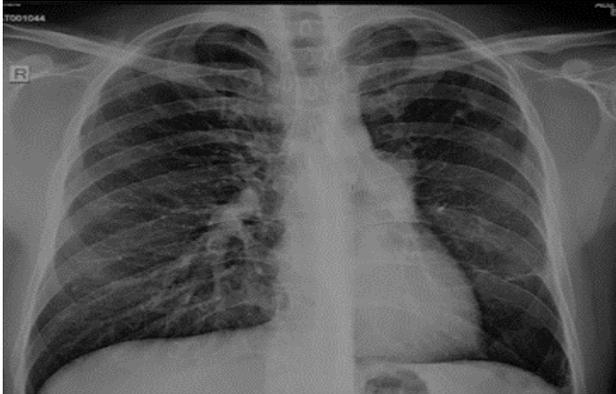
Chest x-ray showing abnormal left hilum.
